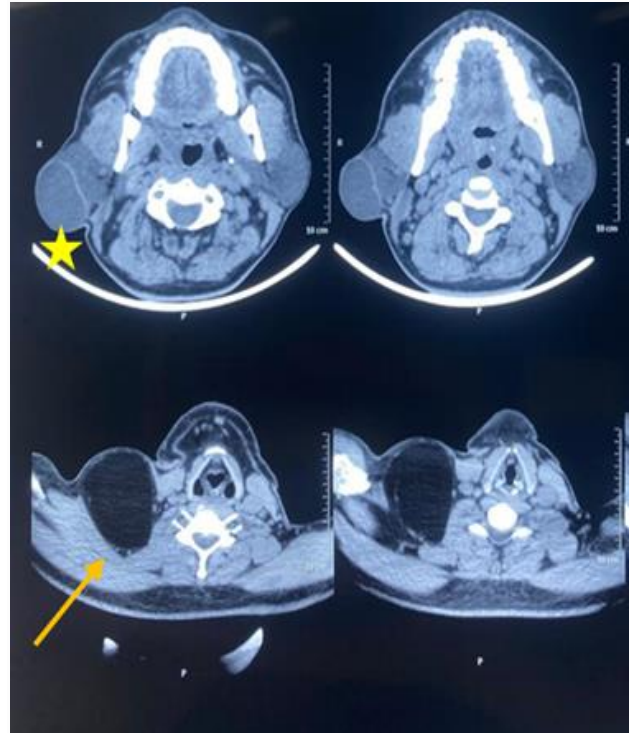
Contrast enhanced computed tomography image-axial sections.
